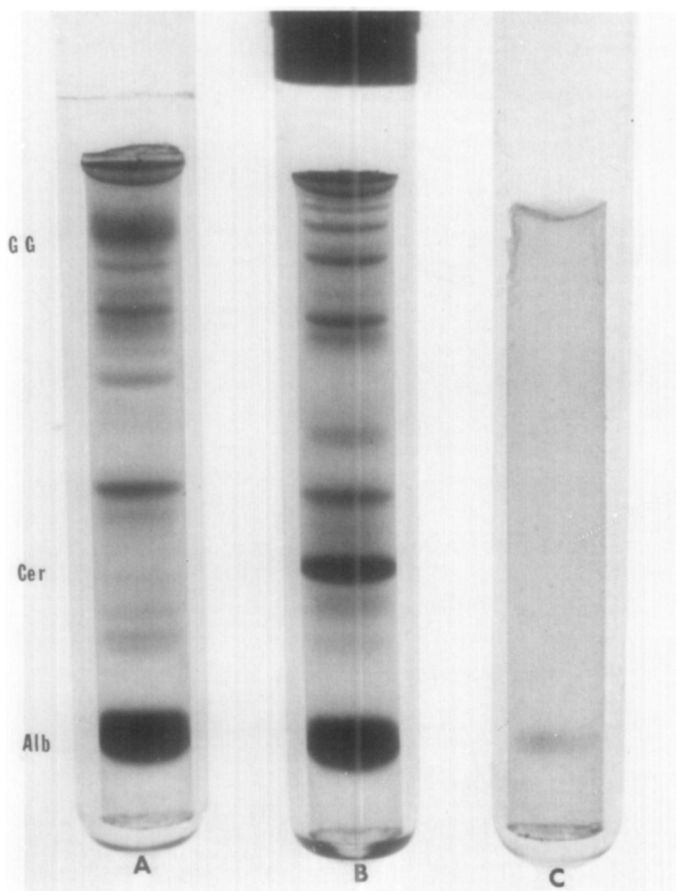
Polyacrylamide-gel electrophoretic patterns from Case 1; periapical granuloma. *A*, Fingertip plasma. *B*, Periapical plasma. *C*, Root canal fluid. *Alb*, Albumin; *Cer*, ceruloplasmin region; *GG*, gamma globulin region.
